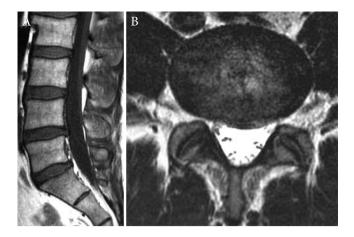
Postoperative magnetic resonance imaging (MRI) showing a hematoma disappeared on T1-weighted sagittal imaging (A) and T2-weighted axial imaging (B).
